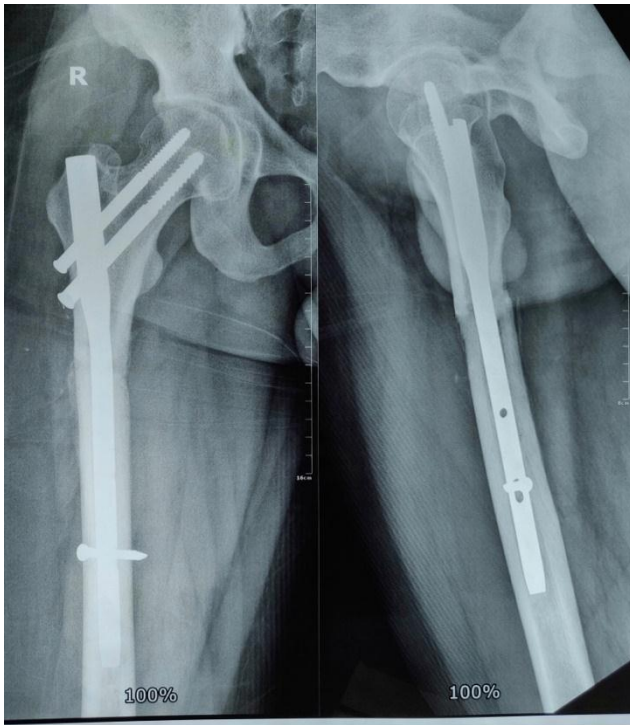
X-ray at final follow up (24 weeks)
